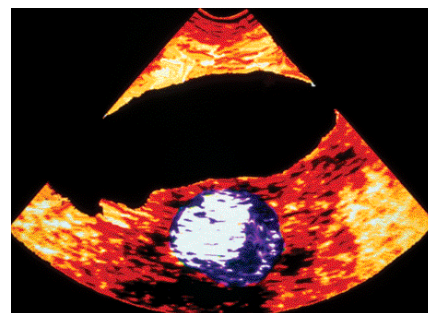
Coloured ultrasound image of bladder and prostate. Urinary ultrasound can show bladder pathology and the degree of residual urine volume and also any enlargement of the prostate.
